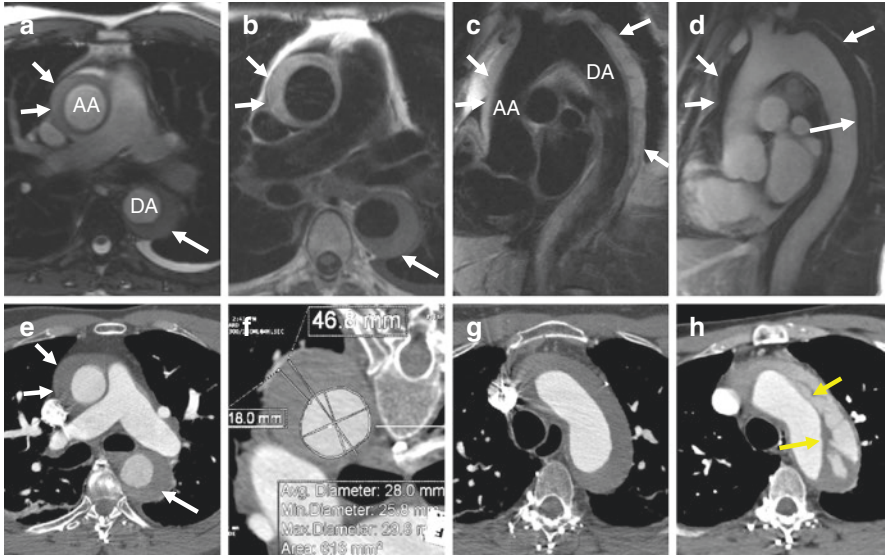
Near concurrent MRI (a-d) and CT (e-h) images of a 65-year old man with chest and back pain demonstrate acute type A IMH (white arrows). Transaxial (a, b) and candy-cane (c, d) magnetic resonance images using single frame from a cine acquisition using steady-state free precession (SSFP) (a), T1-weighted fast spin echo (FSE) with fat saturation (FS) (b), T2-weighted FSE with FS (c), and T1-weighted gradient echo (GRE) with contrast (d). As expected, there is no enhancement of the lesion after contrast. The maximum thickness of the IMH is 18 mm (g) which is believed to be a high-risk feature (>10–16 mm). The patient was initially treated medically. He returned with chest pain one month later and CT revealed (h) that the lesion had converted to a dissection with a complex dissection flap in the aortic arch (yellow arrows). He was subsequently operated on. AA Ascending aorta; DA Descending aorta
